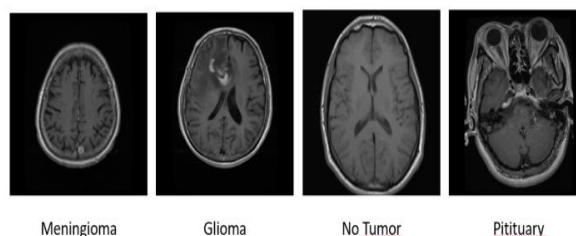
Dataset Description of Brain MRI Images.
